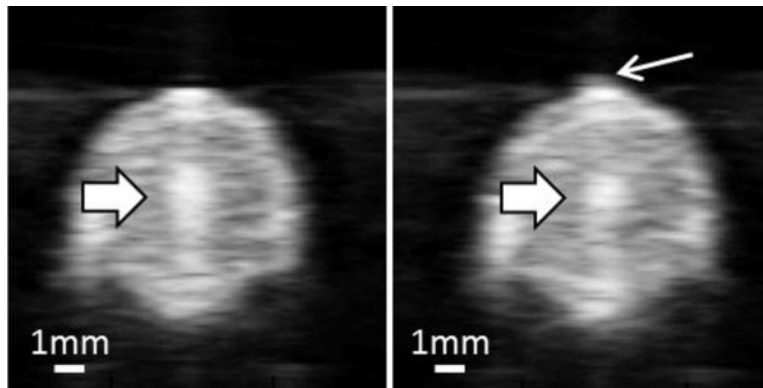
Ultrasound images of vessel lumen during treatment. Left: Focal cavitation at the center of the vessel lumen only (block arrow). Right: Focal cavitation (block arrow) with weak pre-focal cavitation (line arrow).
